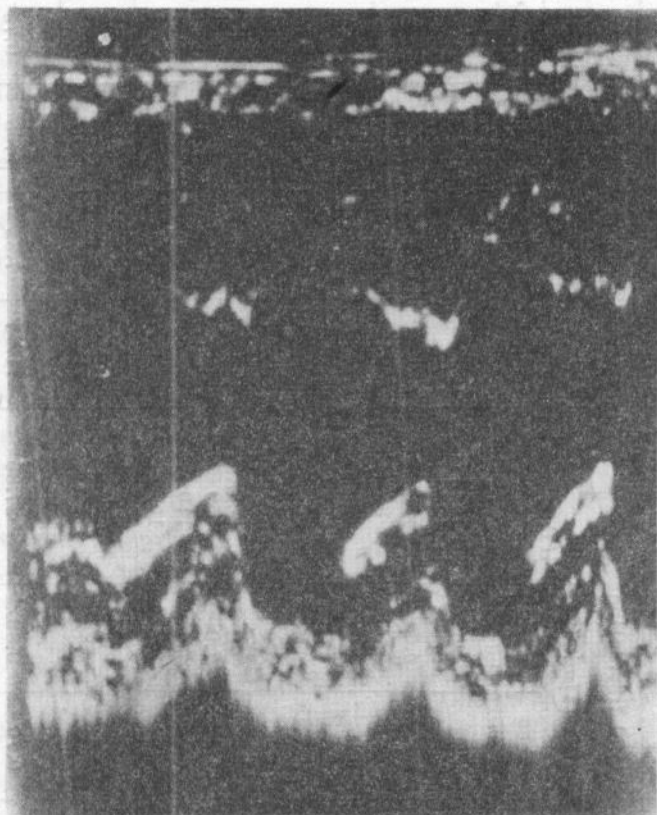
Measuring method of systole and diastole diameter of the left ventricle by the echocardiographic - *TM* technique
